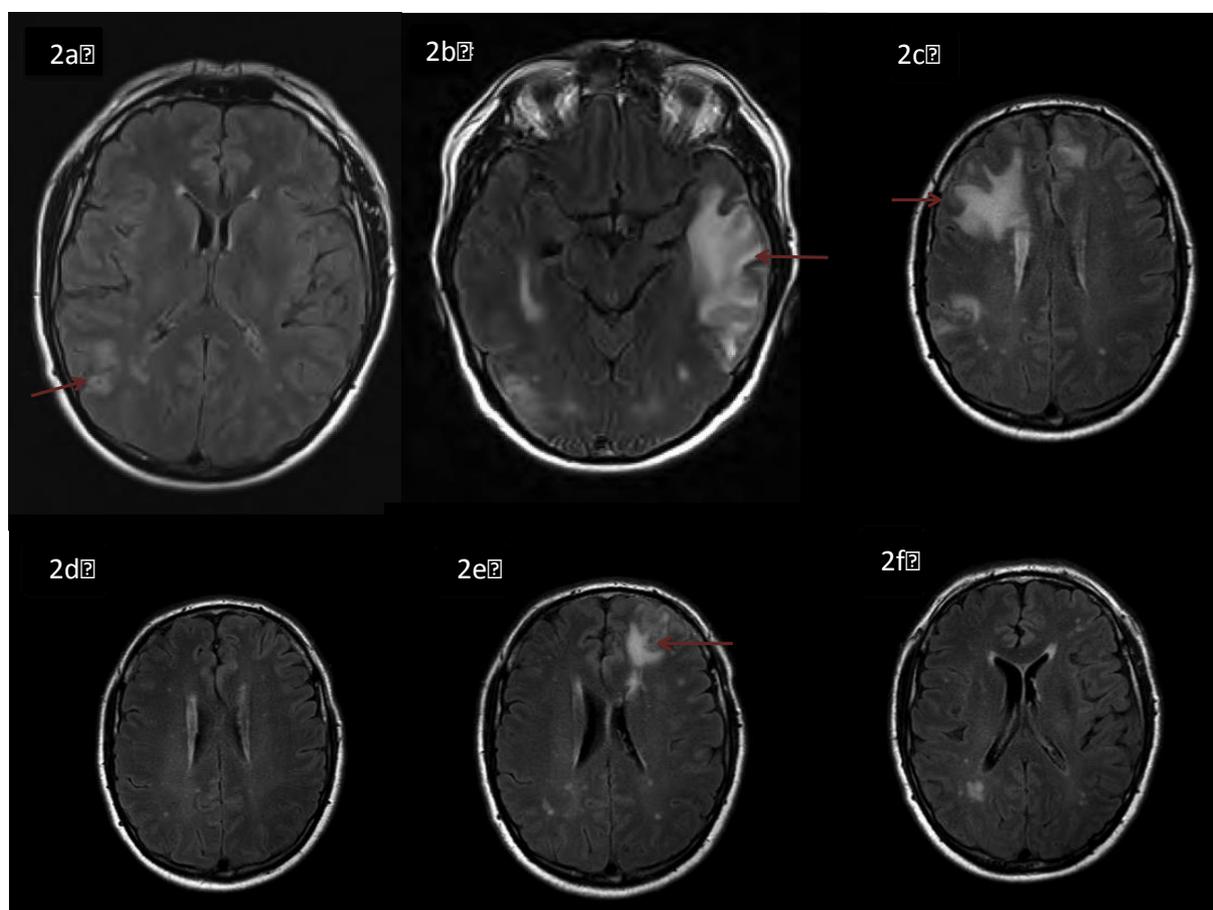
Axial T2 FLAIR MRI brain in 2013 showing subcortical white matter hyperintensities.
